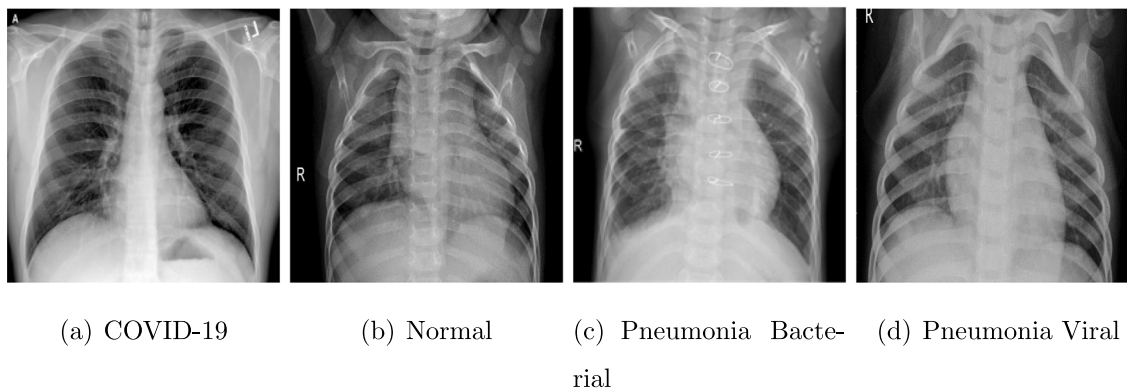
Sample of thoracic X-ray image dataset for four-class instances.
